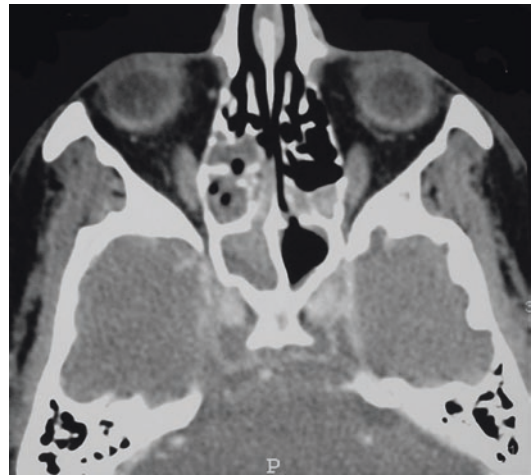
Computed tomography of a subperiosteal abscess of the left eye (a). Patient with severe proptosis and oedema (b)
